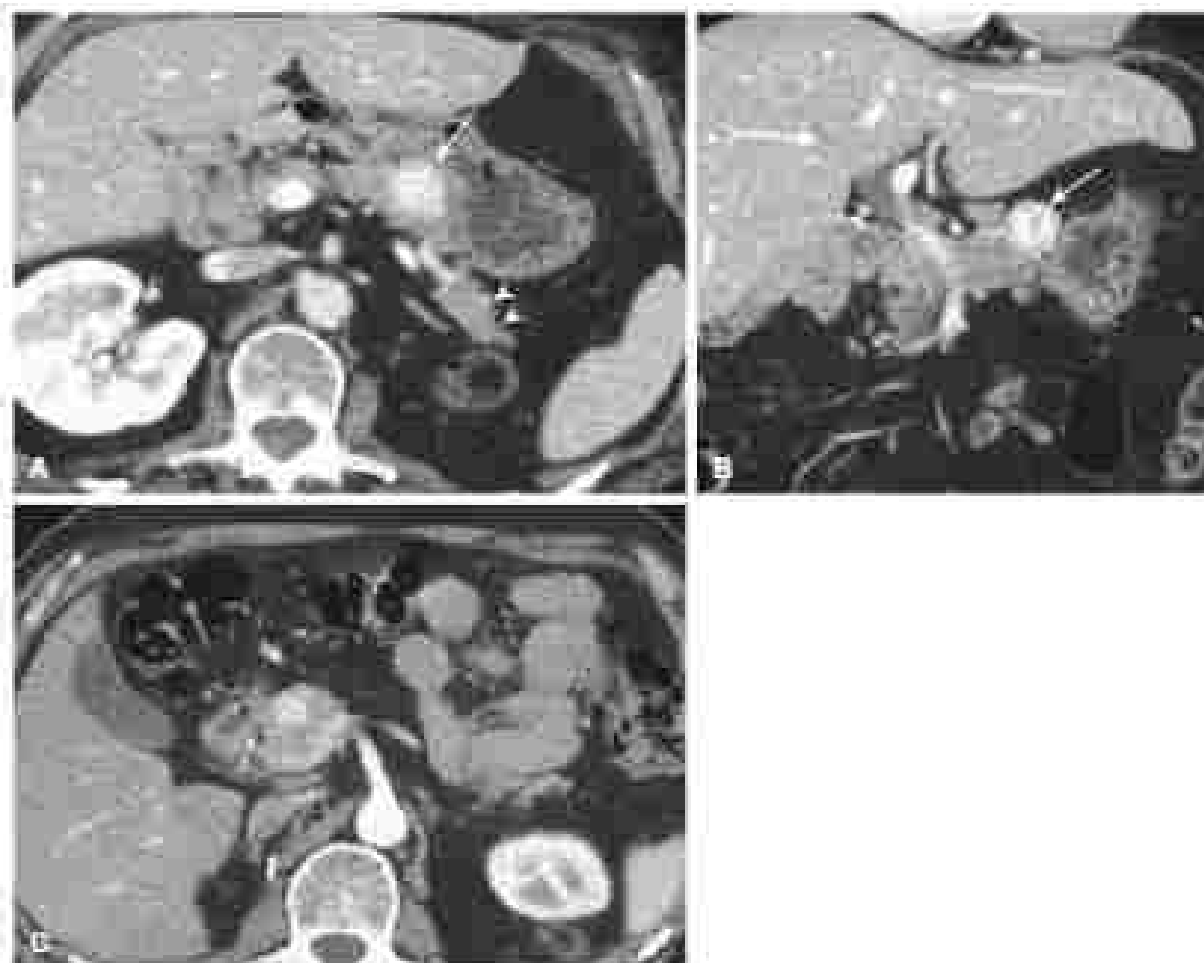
(A, C) Axial and (B) coronal images of a contrast-enhanced computed tomography scan from a patient who underwent a distal gastrectomy for renal cell carcinoma 16 years prior and then developed a neuroendocrine metastasis in the pancreatic body. Note the characteristic bright enhancement of the metastatic lesion (arrow) on arterial phase imaging as well as the posterior displacement of the pancreatic (prestenotic) portion of the stomach of the left kidney.
